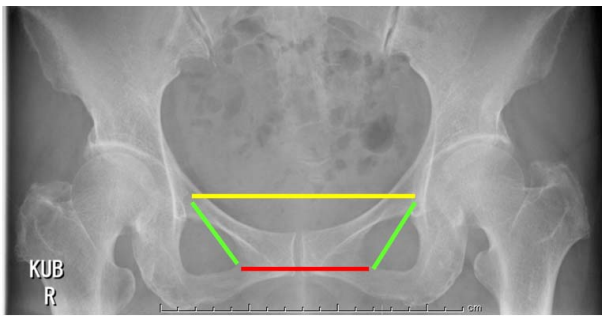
Three parameters are measured from the KUB (abdominal X-ray) before the every TVM surgery. Yellowish line indicates the distance between the bilateral ischial spine, red line indicates the distance between the obturator foramen, and green line is the length of ATFP.
